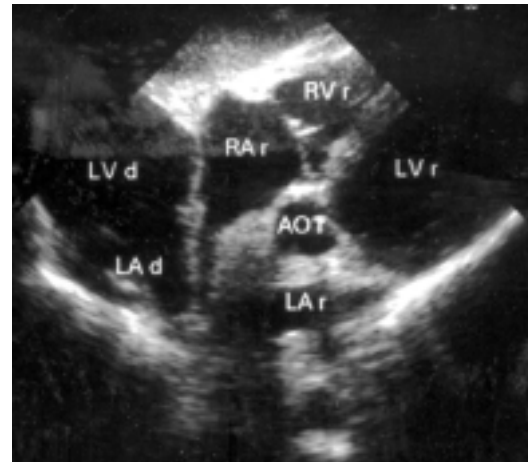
Echocardiogram demonstrating donor's (d) and recipient's (r) hearts. LA = left atrium, LV = left ventricle, RA = right atrium, RV = right ventricle, Ao = Aorta
